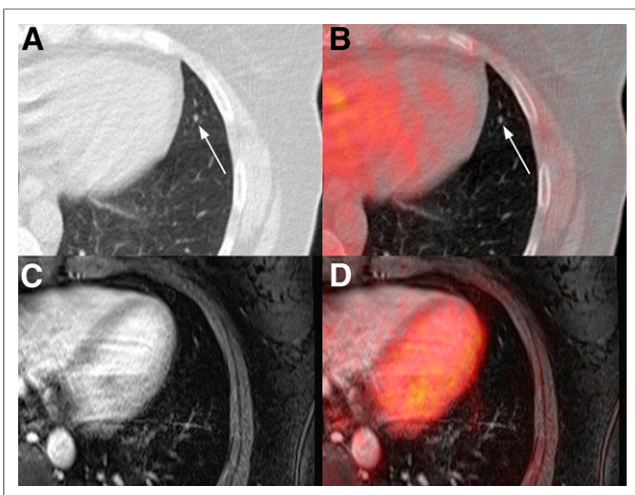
In 46-year-old woman with breast cancer, 4-mm nodule (arrows) is seen in lingula segment of left upper lobe of lung on CT component (A) of PET/CT (B) but not on MRI component (C) of PET/MRI (D). No ^{18}F -FDG uptake is seen on PET component of either PET/CT (C) or PET/MRI (D).
